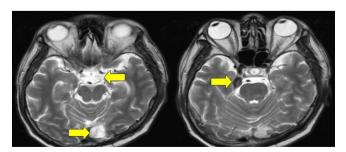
Cranial MRI showing increase in the size of the masses in the left occipital and middle aspect of the right middle cranial fossa. A new lesion was seen in the middle aspect of the left middle cranial fossa in the left parasellar region measuring $0.7 \times 0.5 \times 0.6$ cm (as pointed by an arrow).
